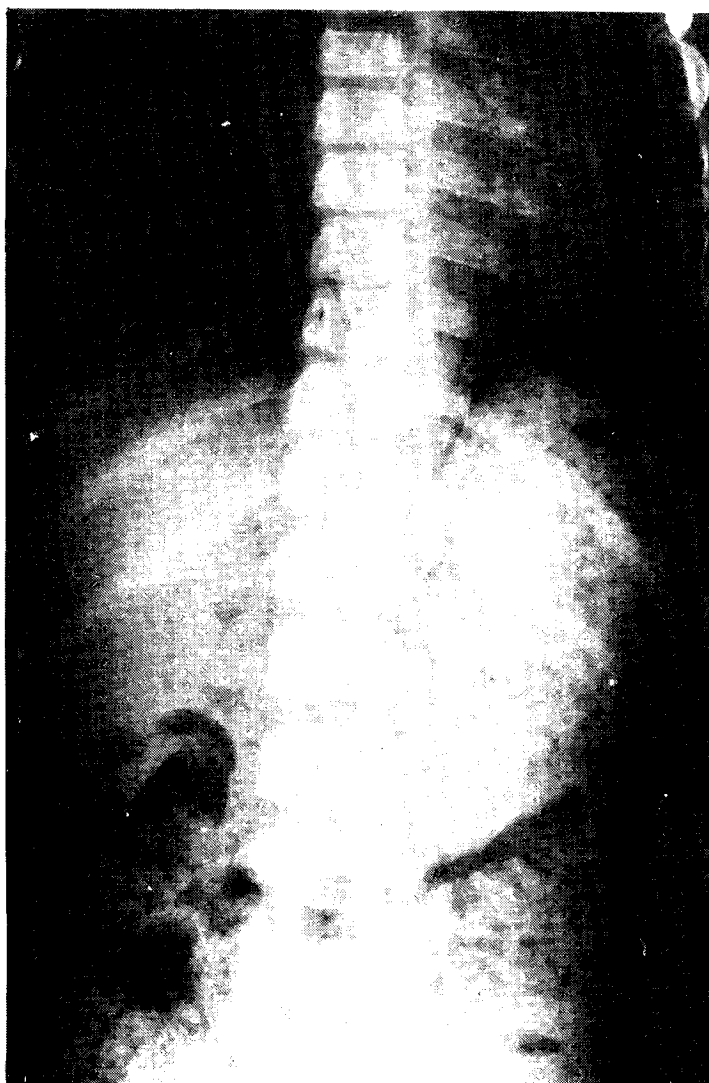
X-ray finding of simple abdomen revealed linear calcification along the aortic border.
